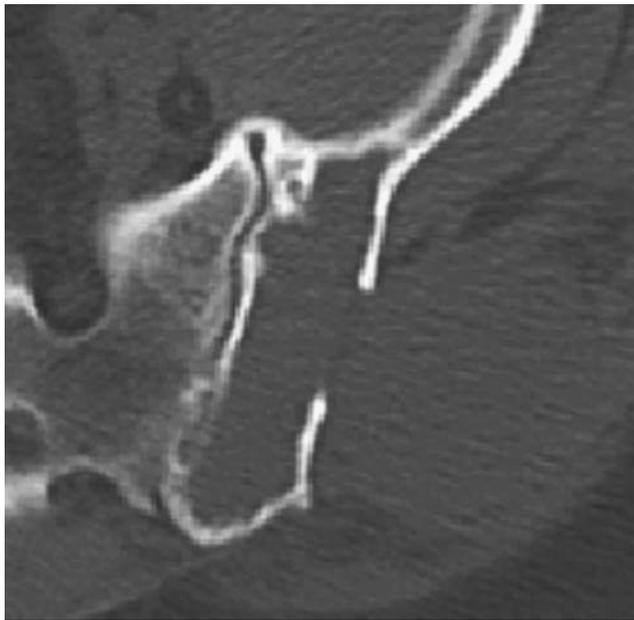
Axial computed tomographic scan shows a soft tissue density mass arising in the posterior ilium that erodes the cortex and extends in the soft tissues forming a large component in the gluteal region. The bone margins are well defined.
